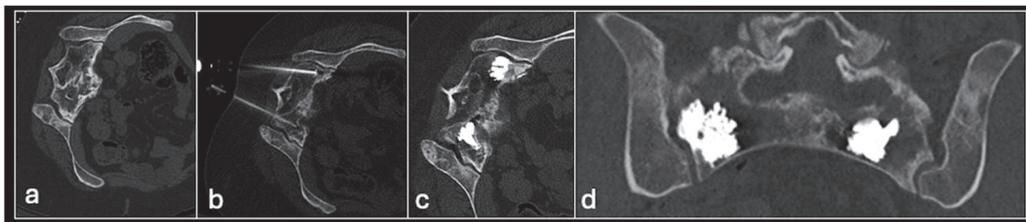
Axial CT (a) showing metastasis in the sacrum. Images (b–d) showing sacroplasty with cement in both sacral ala.
